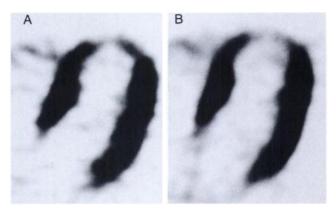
An example of transaxial images in a nondiabetic patient obtained during insulin clamping (A) and after acipimox in the fasting state (B) (50 min after [¹⁸F]FDG injection). The image quality was comparable, and the distribution of [¹⁸F]FDG uptake was similar during both approaches.
